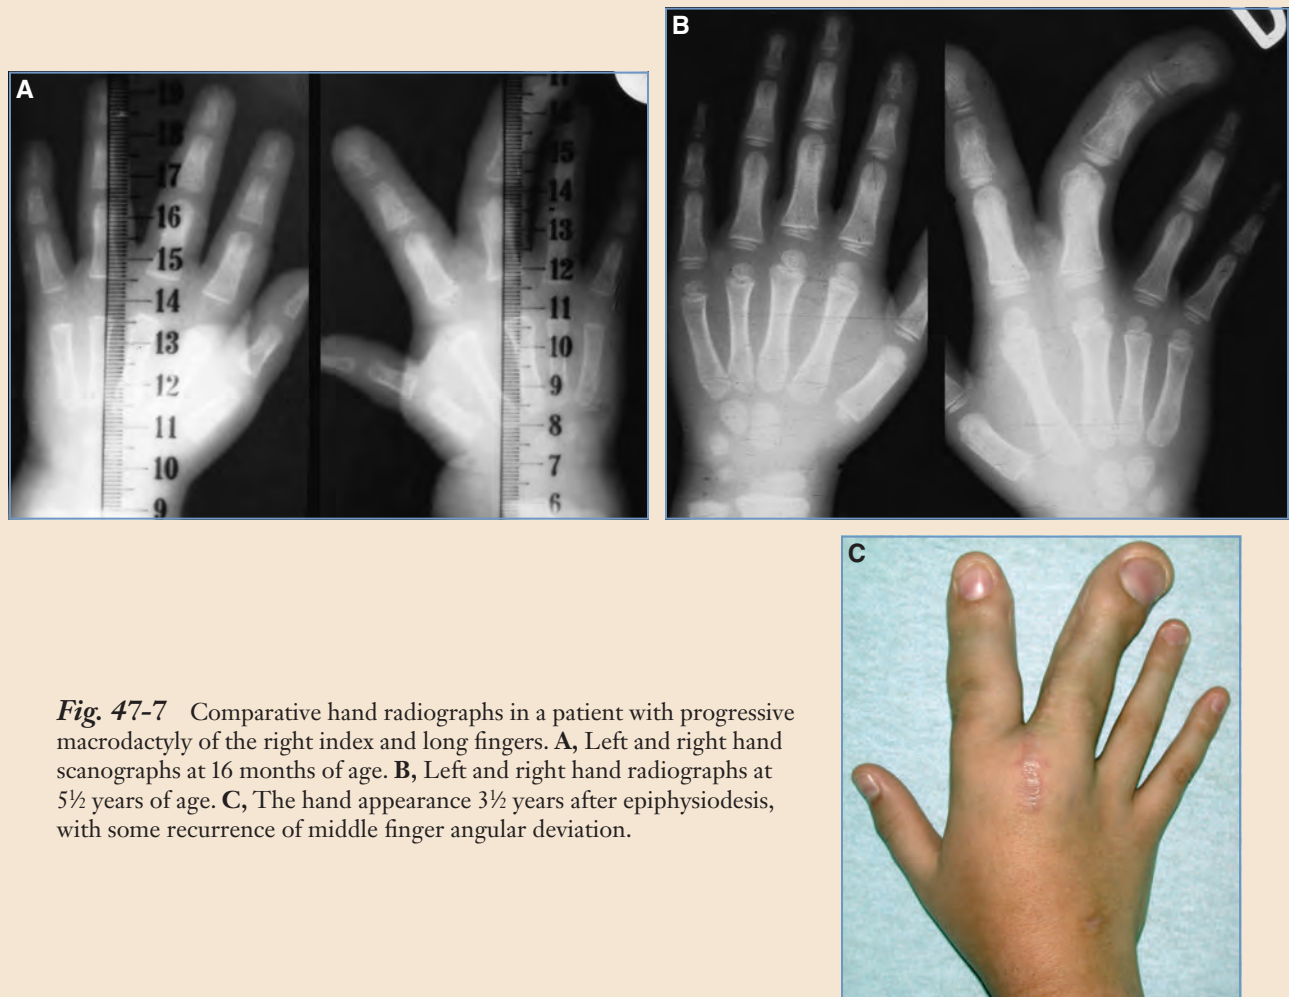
Comparative hand radiographs in a patient with progressive macrodactyly of the right index and long fingers. A, Left and right hand scanographs at 16 months of age. B, Left and right hand radiographs at 5½ years of age. C, The hand appearance 3½ years after epiphysiodesis, with some recurrence of middle finger angular deviation.
